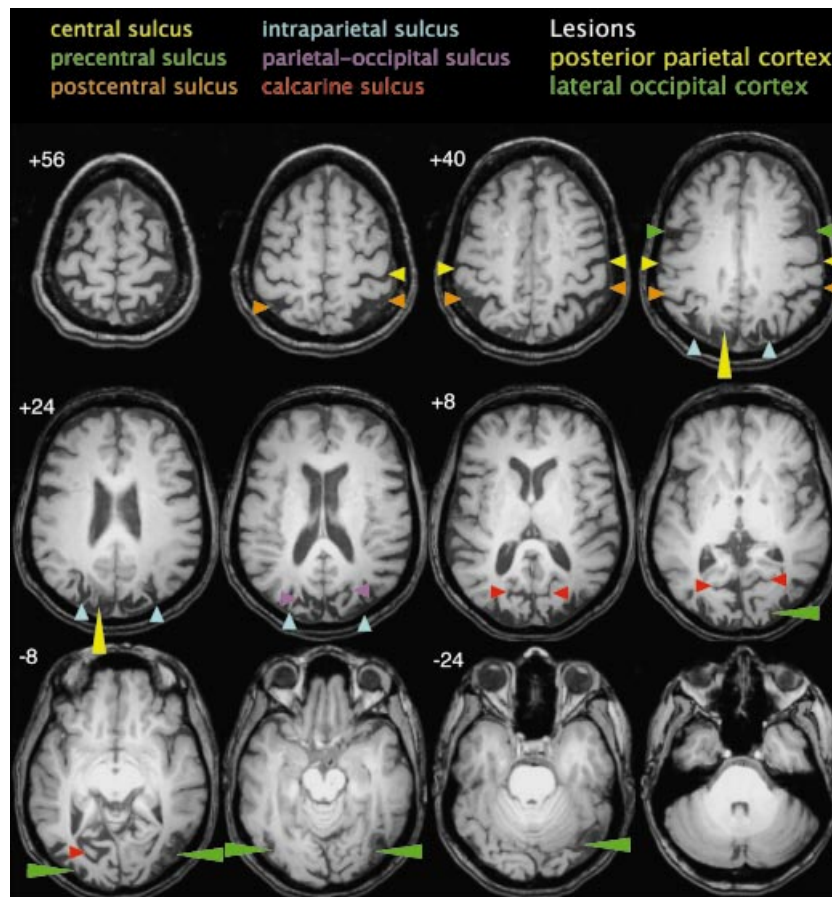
High-resolution structural MRI from Patient D.F. The left side of the brain appears on the left side of the image. Numbers represent deviations (mm) from the anterior commissure–posterior commissure plane (z value in Talairach space). Small arrowheads indicate areas of atrophy and long arrowheads indicate lesioned areas. Small arrowhead colours identify the regions of atrophy: yellow = postcentral sulcus; orange = central sulcus; green = precentral sulcus; blue = intraparietal sulcus; magenta = parietal-occipital sulcus; red = calcarine sulcus. Long arrowhead colours identify the lesions: yellow = posterior parietal cortex; green = lateral occipital cortex.
